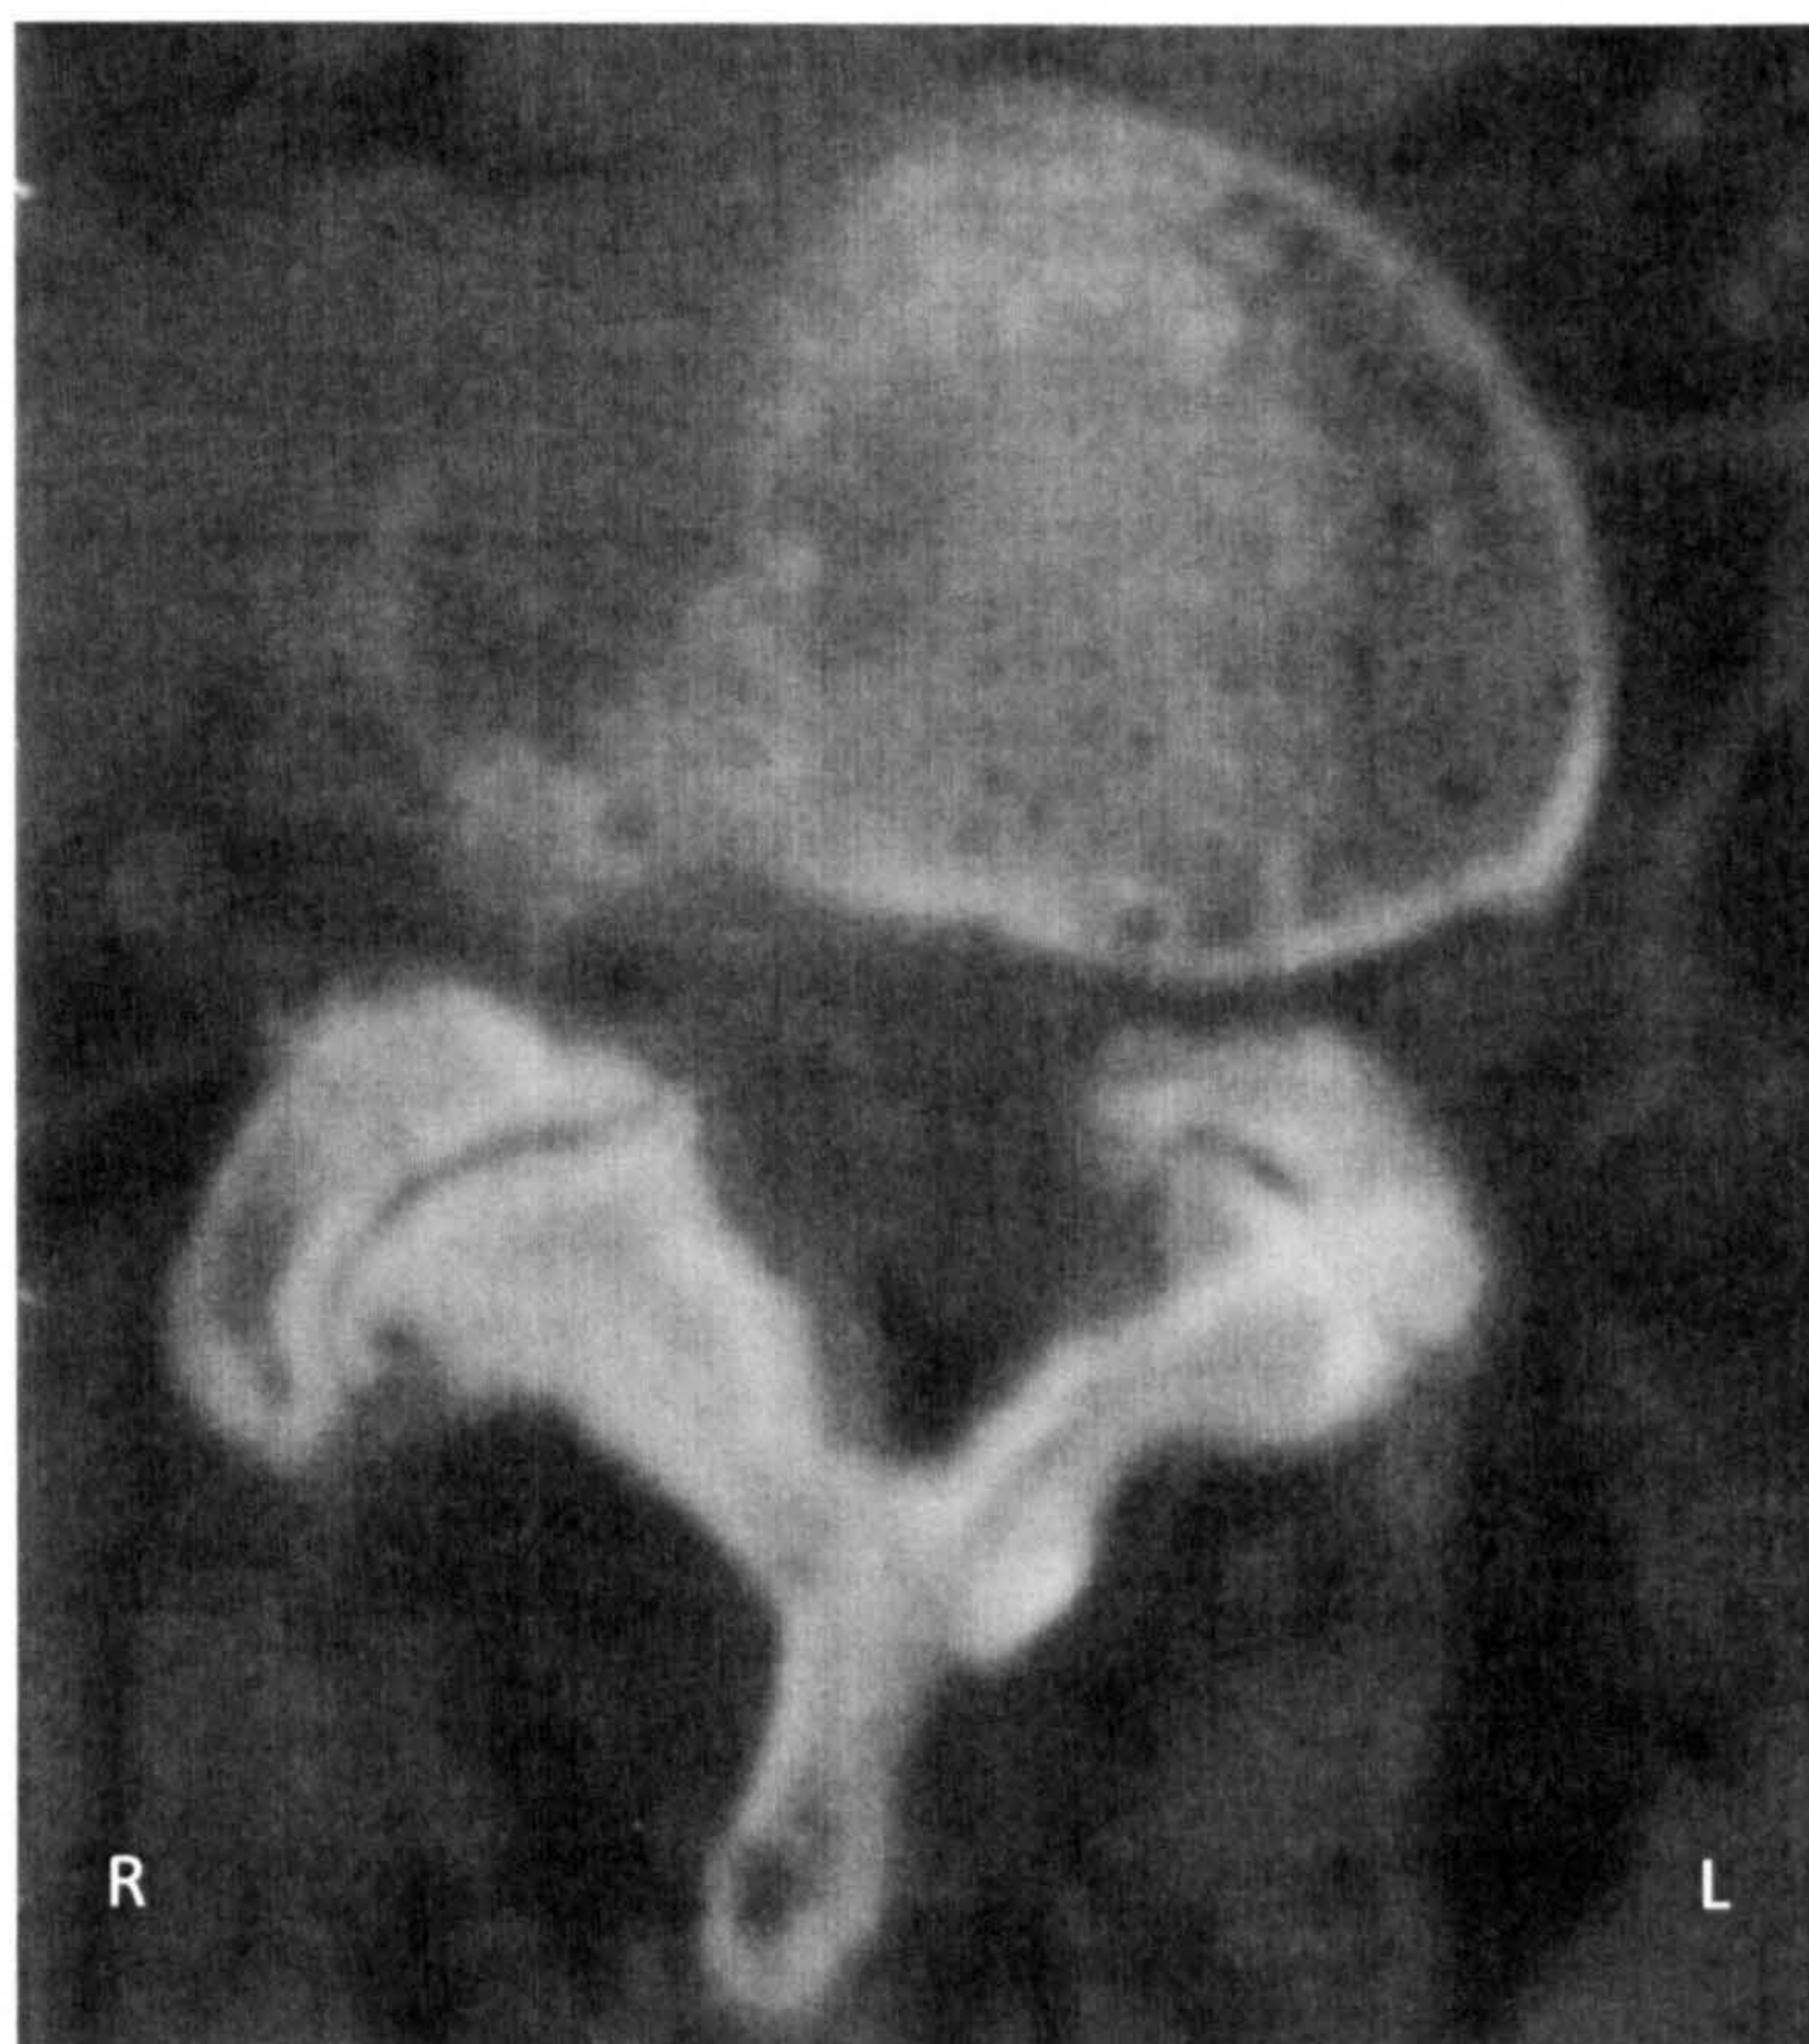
Computerised tomography (CT) scan showing advanced right lumbar facet OA with large osteophyte (Source: Adapted from Sarazin *et al.* (1999:94). Original Figure No. 1).
